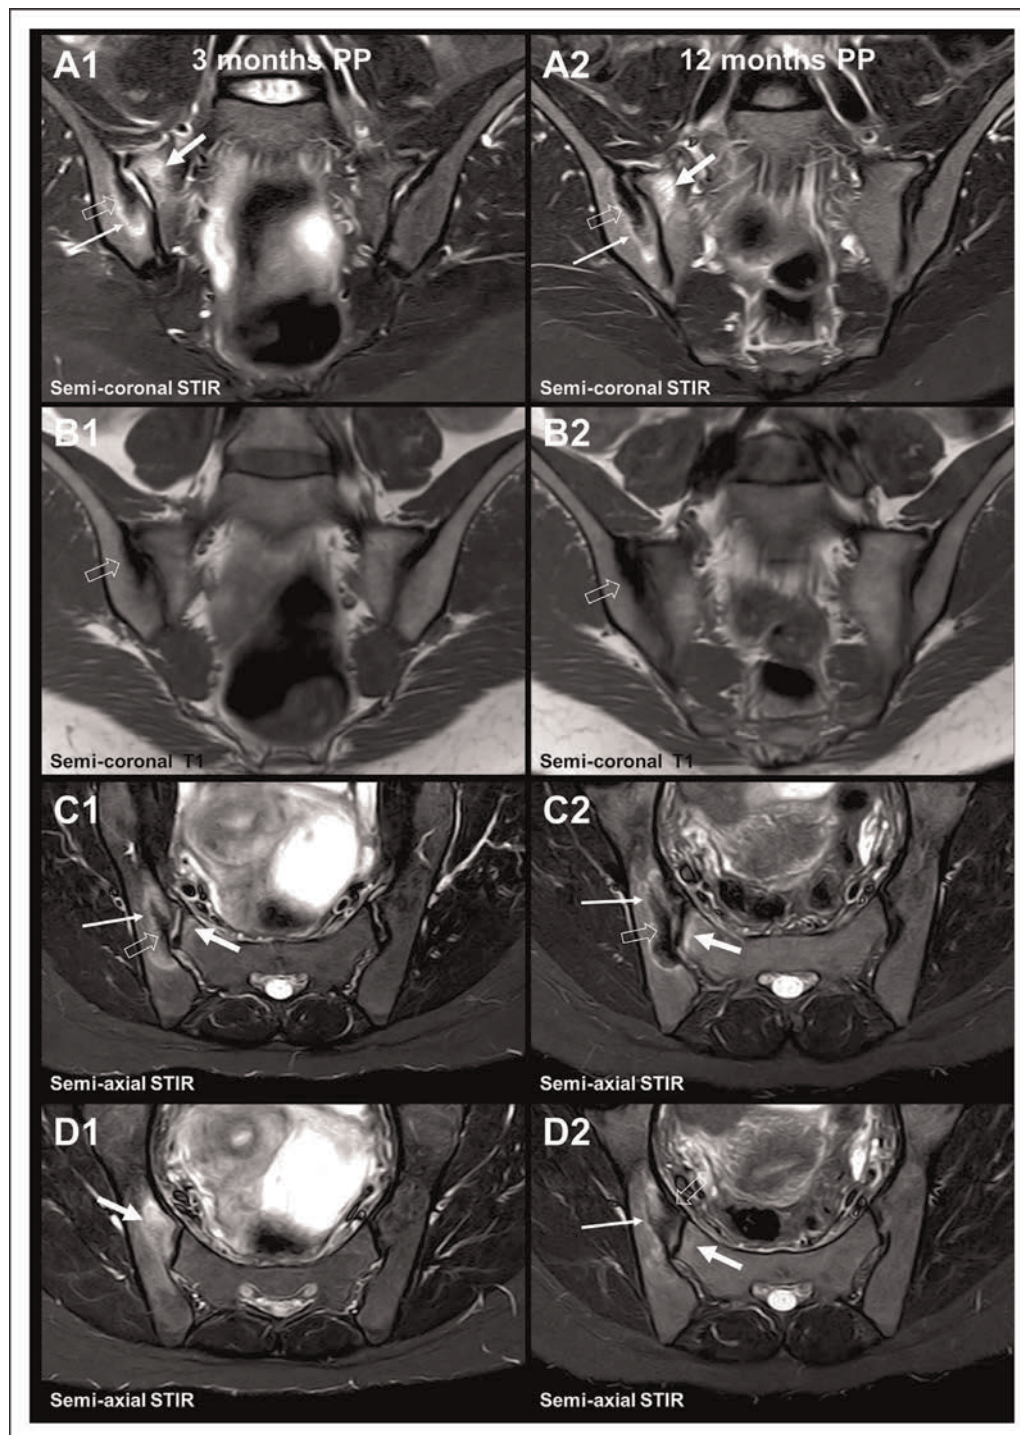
Postpartum changes. MRI in a 32-year-old volunteer woman without any back pain; normal CRP and HLA-27 negative. Semi-coronal STIR and corresponding T1-weighted images anteriorly in the joints and two semi-axial STIR images in the middle part of the joints at 3 months (a1, b1, c1, d1) and 12 months postpartum (a2, b2, c2, d2). Three months postpartum, there is pronounced subchondral BME in the ilium and sacrum at the right SIJ (arrows on a1, c1, d1) with additional subchondral sclerosis in the ilium (open arrows on a1, b1, c1) surrounded by a continuous rim of edema (slim arrows on a1, c1). At 12 months postpartum, the subchondral iliac BME is diminished, whereas the sclerosis has progressed (open arrows on a2, b2, c2, d2), and there is still a rim of edema at the periphery (slim arrows on a2, c2, d2). The sacral edema has increased in intensity as well as extent (arrows on a2, c2, d2). BME, bone marrow edema; CRP, c-reactive protein; PP, postpartum; SIJ, sacroiliac joint; STIR, Short Tau Inversion Recovery.
